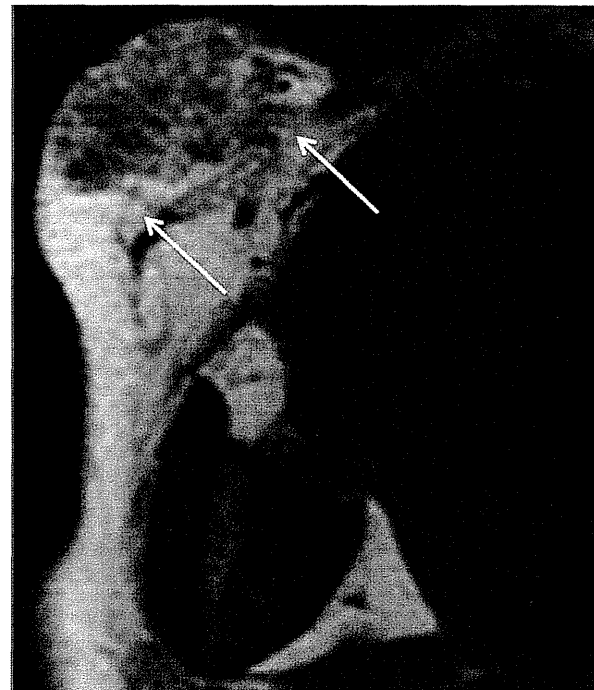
Infantile hemangioma in the involuting phase on the right mandible of a 2-year-old boy who received laser treatment. Axial T1-weighted MR image shows a mass including loose fibrofatty tissue (*arrows*)
